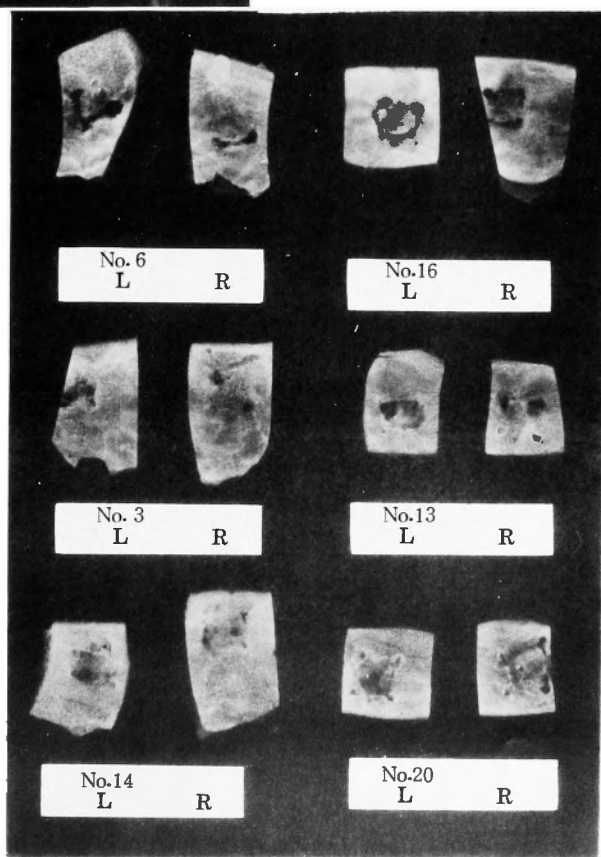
Roentgenograms of removed fibulas. Nearly one year after transplantation.
